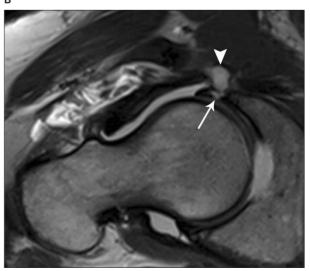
Paralabral cyst and labral tear in a 14-year-old girl. A, Sagittal sonogram of the anterior hip showing a labral tear as a hypoechoic cleft (arrow) at the junction of the labrum and acetabulum with an adjacent hypoechoic paralabral cyst (arrowheads). B, Oblique T1-weighted magnetic resonance (MR) image after intra-articular administration of diluted gadolinium showing contrast filling the labral tear (arrow) and adjacent contrast-filled paralabral cyst (arrowhead). C, Transverse sonogram of the anterior hip showing the hypoechoic paralabral cyst (arrowheads) adjacent to the anterior cortex of the acetabulum. D, Axial T1-weighted MR image after intra-articular administration of diluted gadolinium showing contrast filled paralabral cyst (arrowhead). E, Oblique T1-weighted MR image after intra-articular administration of diluted gadolinium showing contrast filling the labral tear (arrow) and adjacent contrast-filled paralabral cyst (arrowhead). E, Oblique T1-weighted MR image after intra-articular administration of diluted gadolinium showing contrast filling the labral tear (arrow) and adjacent contrast-filled paralabral cyst (arrowhead). F, Sagittal T1-weighted MR image after intra-articular administration of diluted gadolinium showing contrast filling the labral tear (arrow) and adjacent contrast-filled paralabral cyst (arrowhead).
